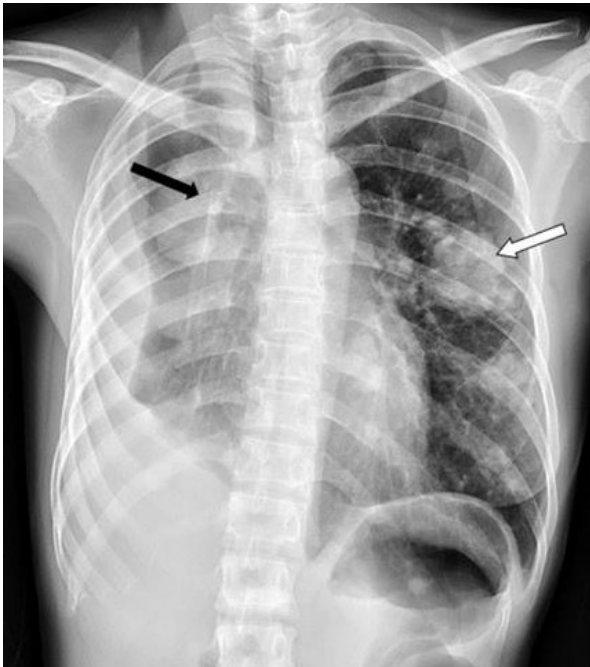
Chest radiograph revealed right upper lung cancer with left lung metastasis and right massive pleural effusion.
